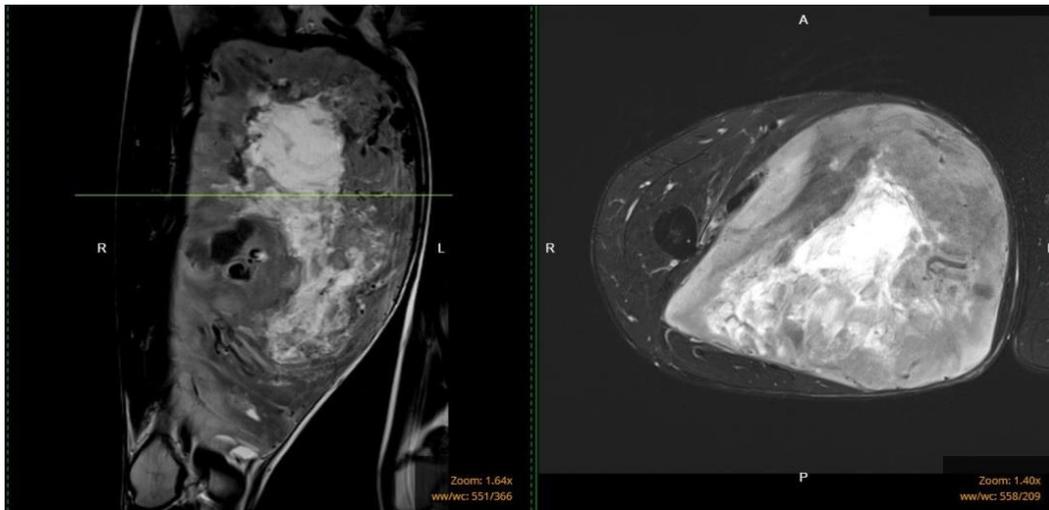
T2 weighted MRI images of the right thigh in axial and sagittal view (tumour cut: around the widest circumference) Sagittal (a) and Axial (b) images depict a hyperintense lesion within the adductor compartment with ill defined margins encapsulating the profunda vessels and abutting the superficial femoral vasculature
